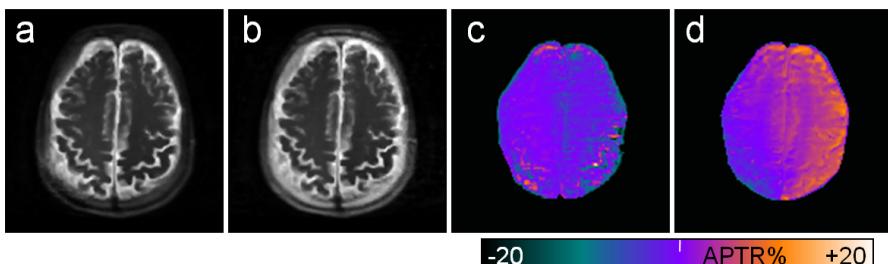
Results from a multi-element transmission based 2D driven-equilibrium APT-MRI sequence on a healthy volunteer: (a) RF saturation at -3.5 ppm, (b) +3.5 ppm, (c) APTR baseline measurement, (d) APTR without δB_0 correction.
